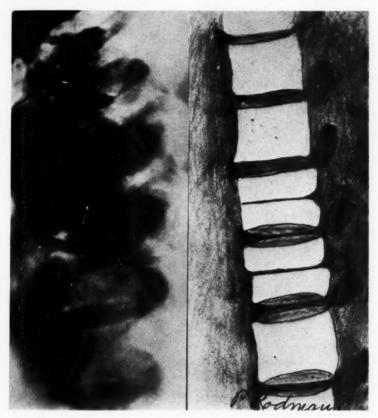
Lateral roentgenogram of the dorsal spine in a man who had sustained injury in a railroad accident. The ninth and tenth vertebræ show transverse linear marks bisecting the vertebræ into two symmetrical halves. The upper half of the body of the tenth dorsal lies fully 3 mm. anterior to the lower half. This case brings up the interesting speculation of a divided vertebra, due either to failure of fusion of the primitive somites or to a persistence of the inter-segmental septum, with a possible displacement of the upper half of the body of the tenth dorsal as a result of the trauma. The twelfth dorsal, which was not included in this roentgenogram, showed a compression fracture.
